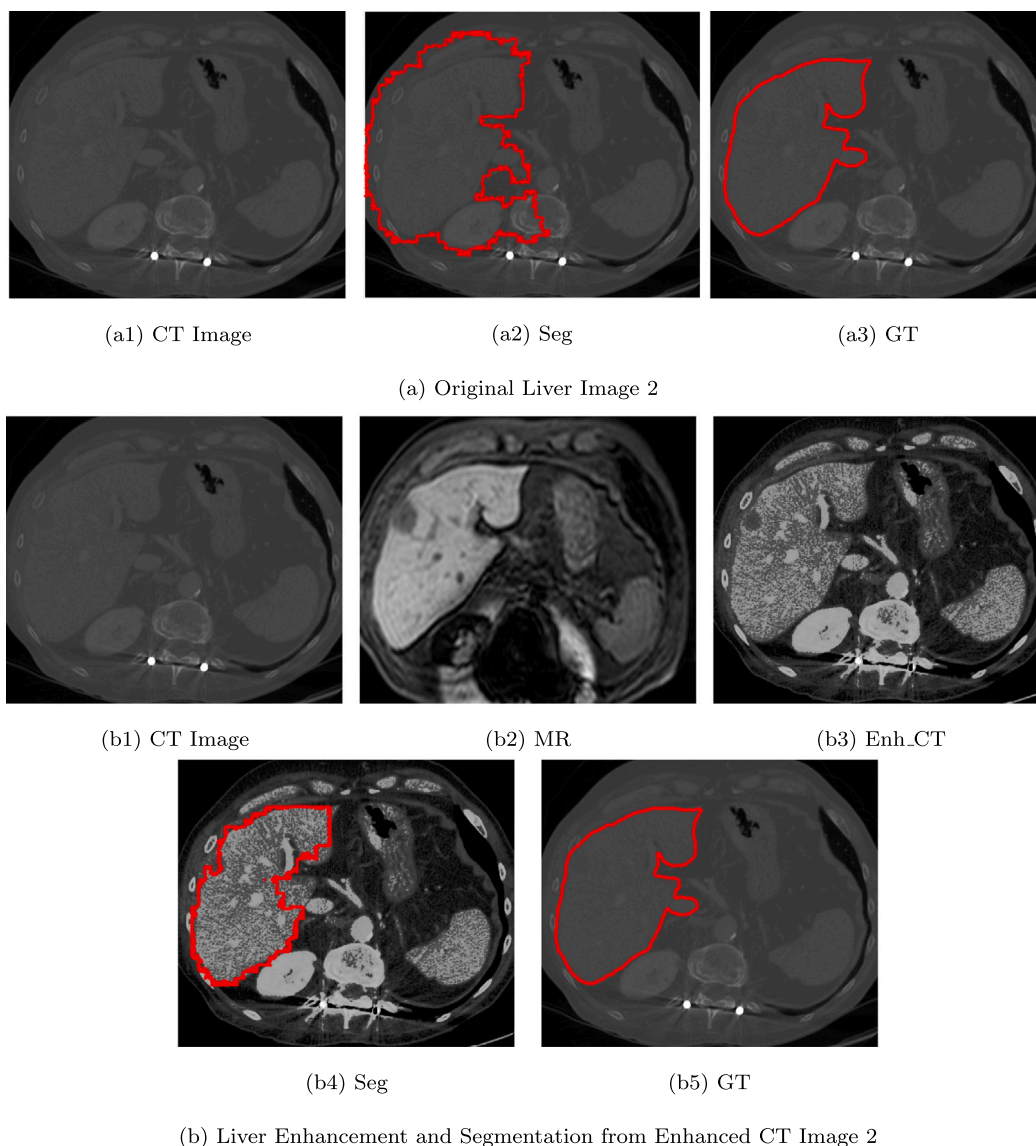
Liver segmentation original and enhanced CT image 2.
